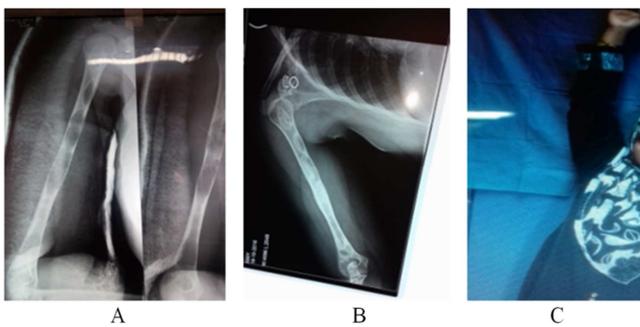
1A, Pre-operative X-ray. 1B, post-operative X-Ray at 2 years (After through curettage the cavity and filled with mixed bone graft) complete healing of lesion. 1C, Post-operative photograph at 2 yrs, full abduction of right shoulder joint.
